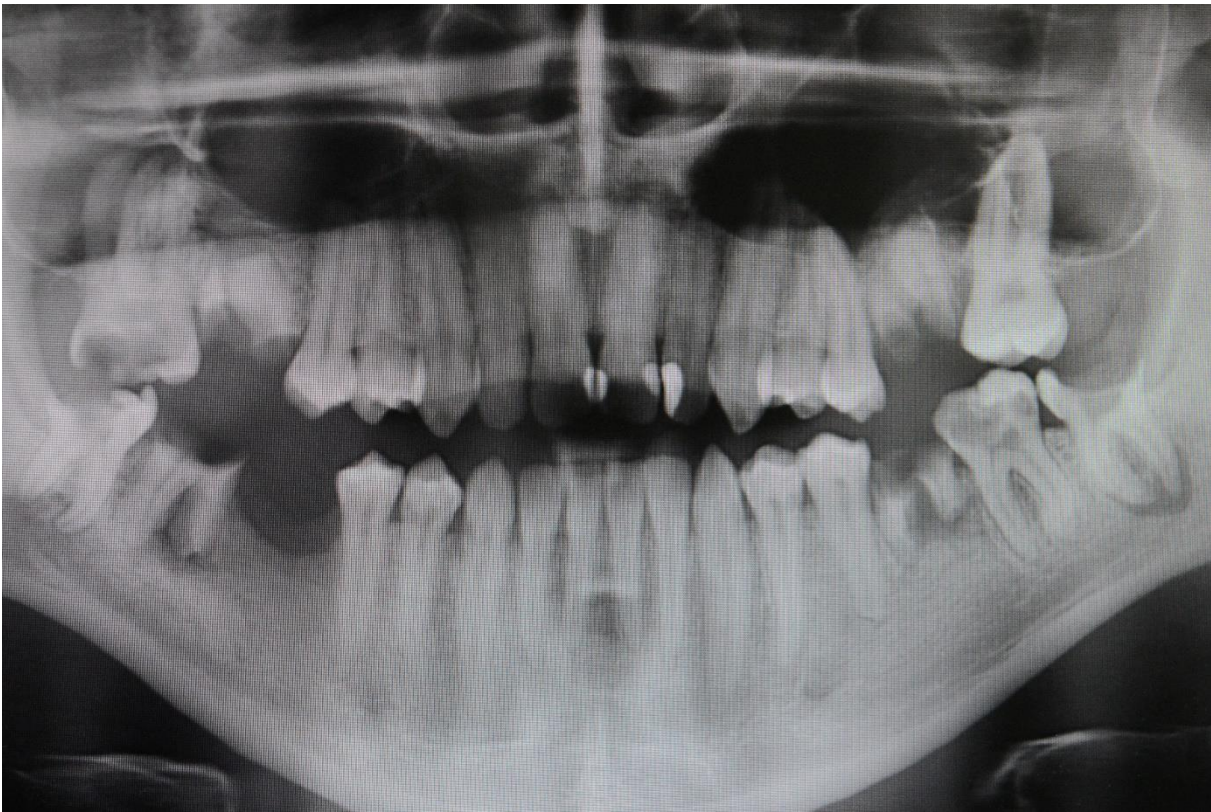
Preoperative panoramic radiograph.
